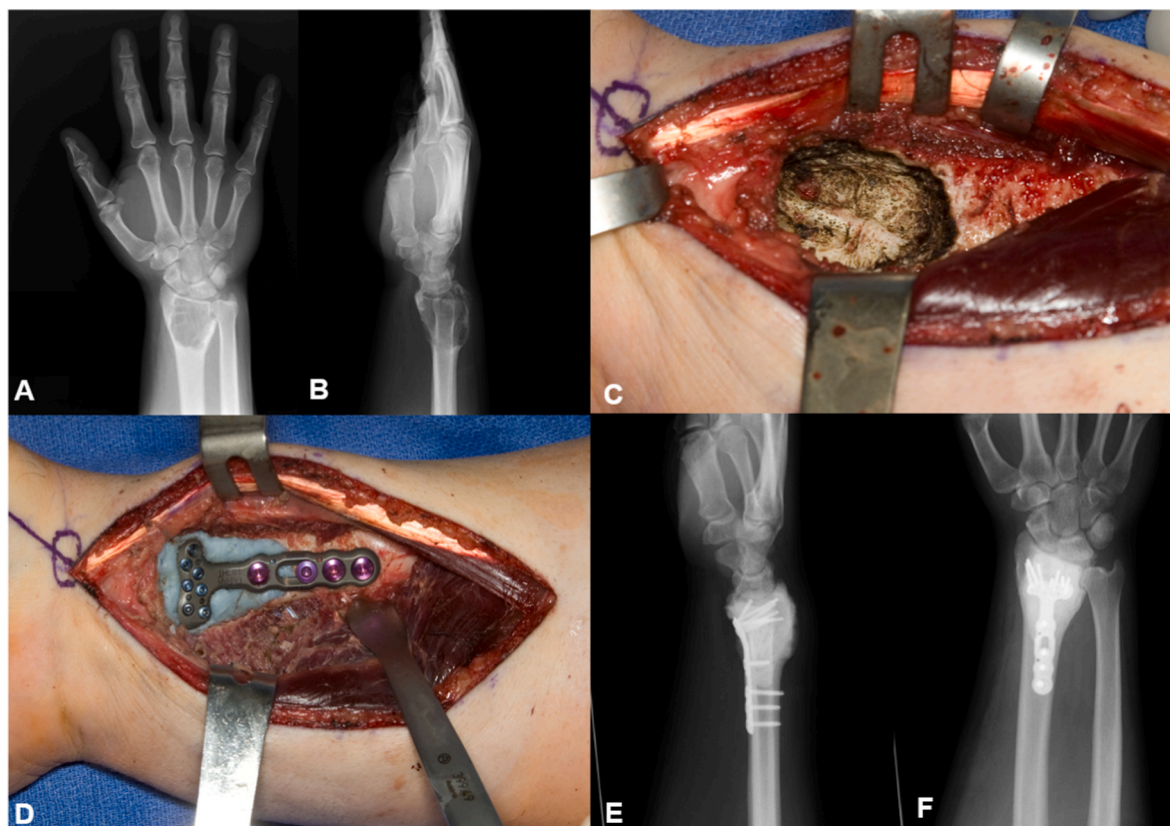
Preoperative AP (A) and lateral (B) radiographs of a patient with a Campanacci Grade 2 GCT of right distal radius. Patient underwent curettage with hydrogen peroxide and argon beam adjuvants (C) followed by fixation with cement and volar plate (D). Post-operative radiographs show cement packing and stabilization of the right distal radius with supported articular surface (E, F).
